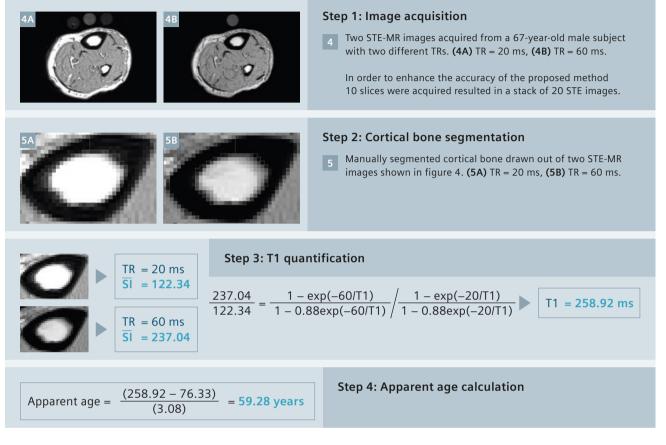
Image acquisition: 	Acquiring two STE-MR images with identical imaging parameters except for TR (TR1 = 20 ms / TR2 = 60 ms).
